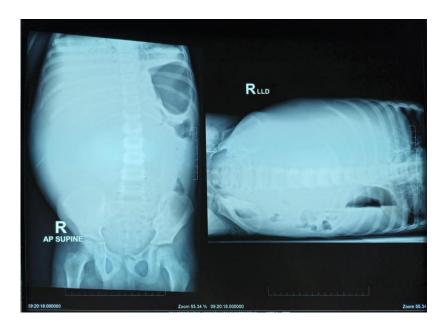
Abdominal x-ray after the first surgery
